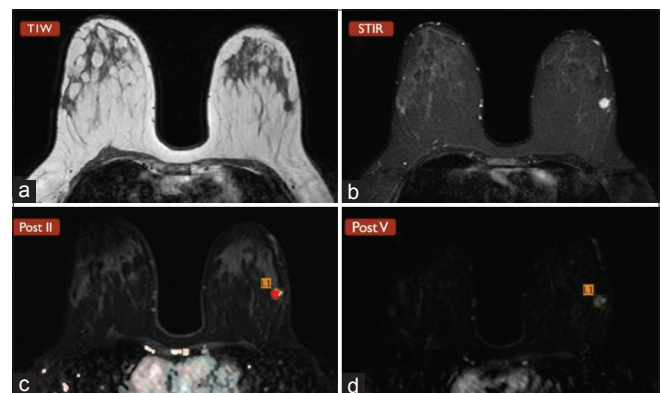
Breast dynamic contrast-enhanced-magnetic resonance imaging of a 39-year-old female with a positive family history of breast cancer who had found a mass in her self-examination; in the ultrasound study, a round hypoechoic lesion without posterior shadow in left breast was reported (Breast Imaging Reporting and Database System 4a). (a) T1-weighted, (b) Short Tau Inversion Recovery (STIR), (c and d) Contrast-enhanced T1-weighted (second and fifth series) show a round mass with smooth border which shows ring enhancement
